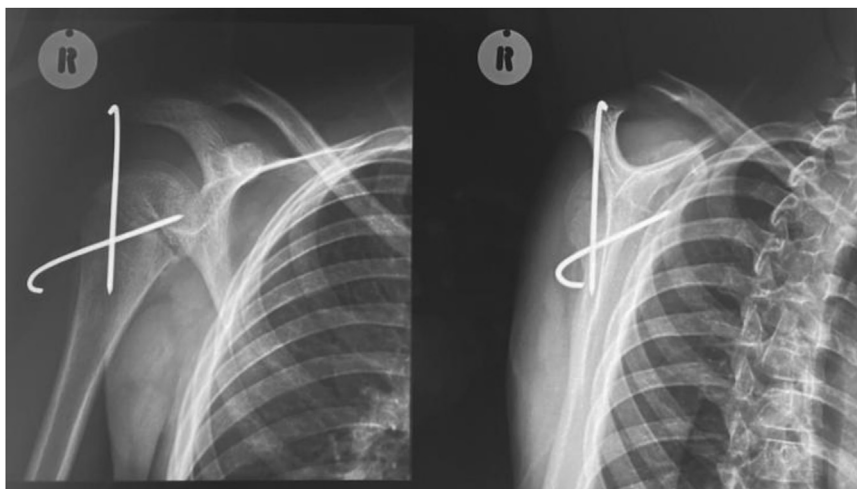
Day 1 postoperative X-ray images of the right shoulder.
